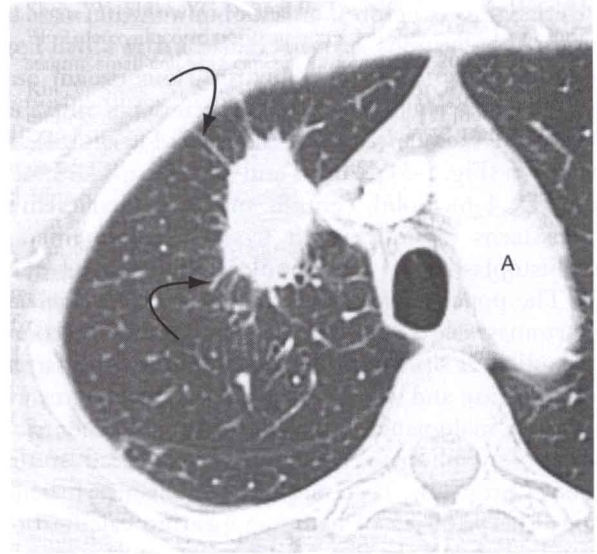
Adenocarcinoma with spiculations in a 61-year-old woman. Contrast-enhanced chest CT scan at the level of the transverse aorta (A) demonstrates a 2.8-cm nodule with spiculations (arrows).
